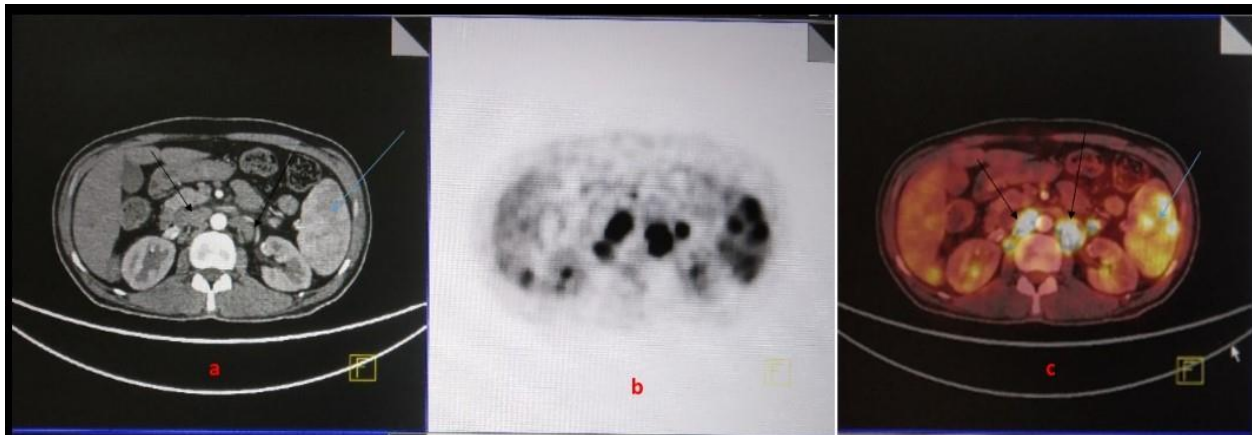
(a) Axial CT scan shows enlarged aortocaval and paraaortic nodes (black arrows) and a normal-sized spleen (blue arrow); nodal involvement was positive and splenic involvement was negative by CT criteria. (b & c) Axial fused PET/CT image shows increased FDG activity in the spleen (blue arrows) and nodes (black arrows); nodal as well as spleen was considered involved by PET/CT criteria.
